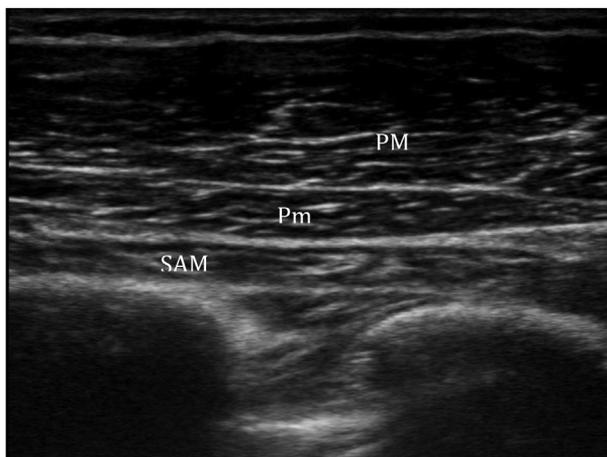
PECS (PM – pectoralis major, Pm – pectoralis minor, SAM – serratus anterior). Ultrasound image of the second injection of PECS II block between Pm and SAM.
